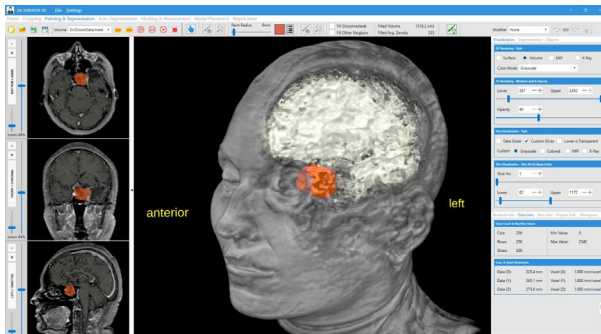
3D image of preoperative MR and CT images of a patient with pituitary adenoma segmented on an Illumetry XR screen integrated with ArSurgeon software developed by SimBT
